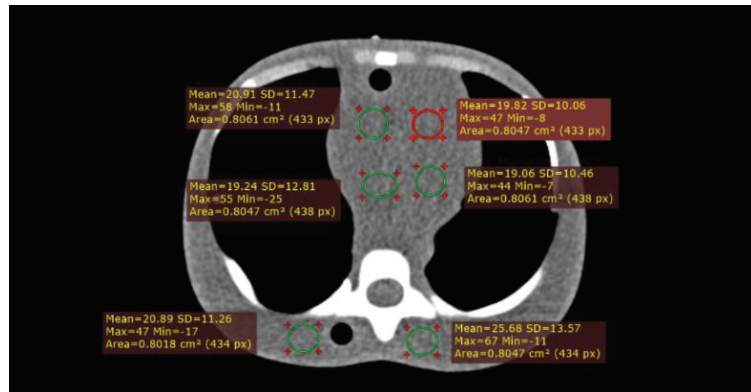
Example of objective image quality analysis of CT number (mean), image noise (SD), SNR, and CNR by putting the region of interest (ROI) in the lungs and soft tissue field.
